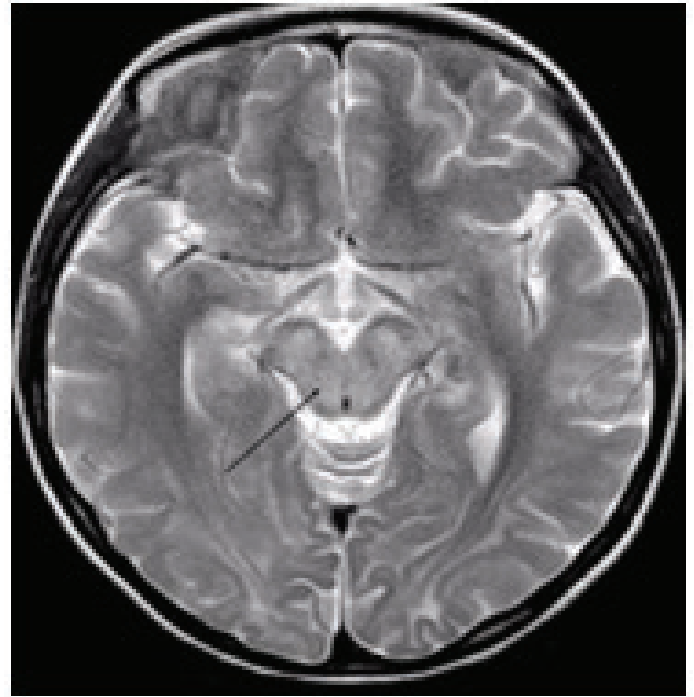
Axial T2-weighted image showing impairment of the midbrain.
